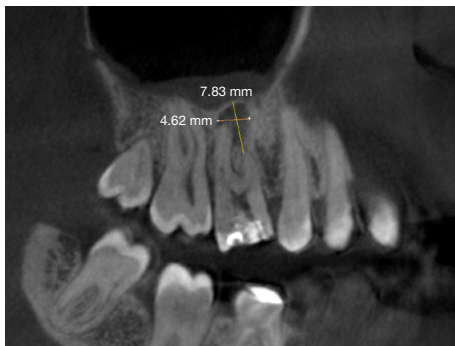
Tooth 1.6 on CT, sagittal plane view.
